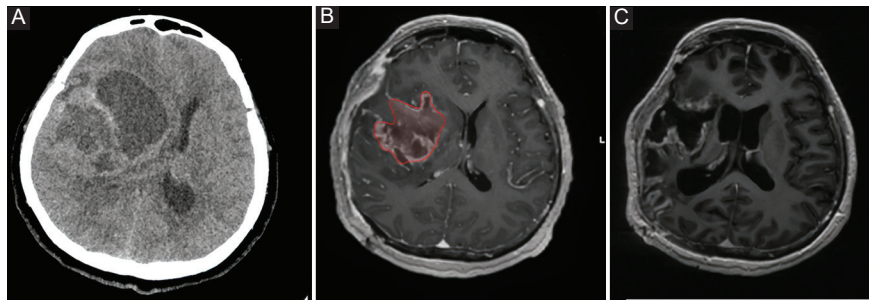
CT scan taken prior to performing an emergency DC. A: immediate postoperative MRI with residual tumor. B: Postoperative MRI showing a GTR of the tumor C:
